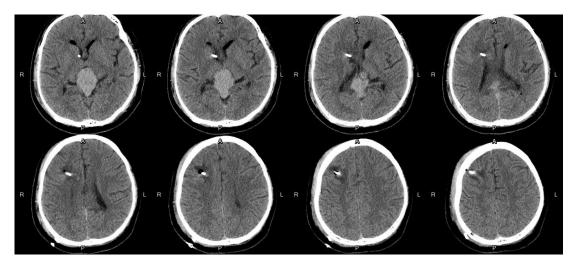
Post operative plain cranial CT scan, post external ventricular device insertion
